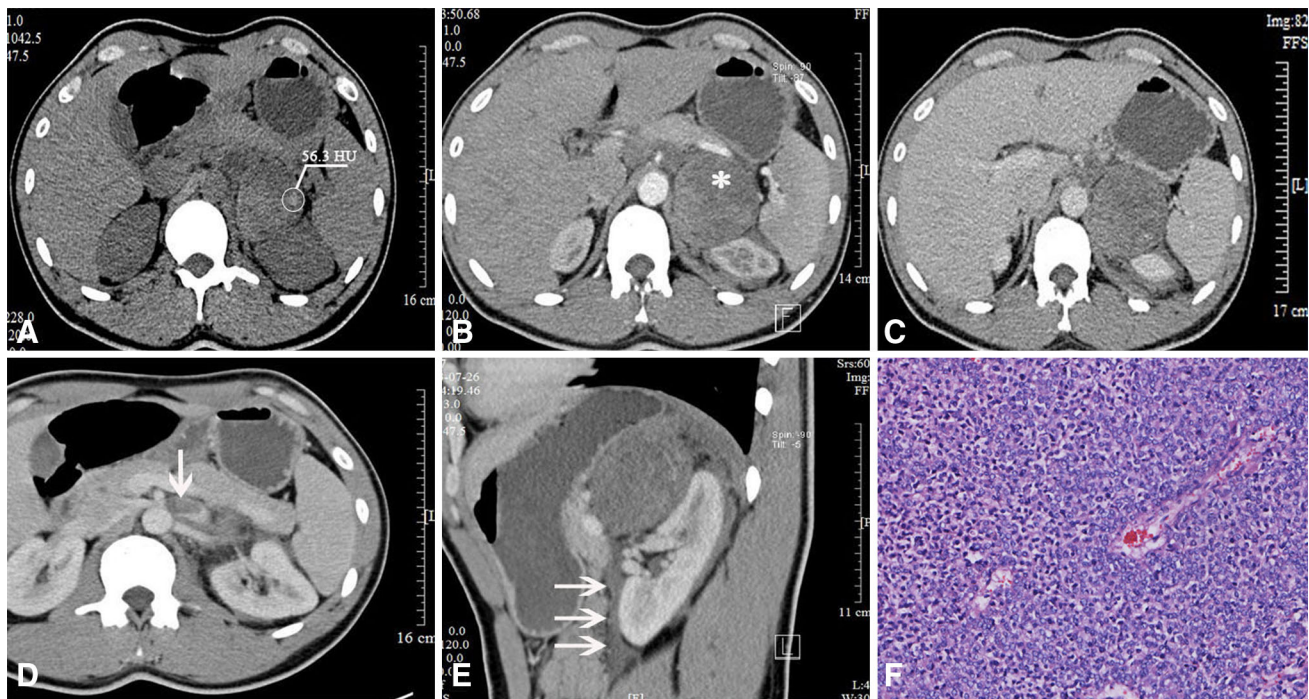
CT findings of a 27-year-old man with an adrenal PNET (case 2). Pre-enhanced CT images showed a well-defined, rounded, soft-density mass on the left adrenal gland. Patchy areas of hemorrhage were observed with a CT value of 56.3 Hu (a). A patchy low
